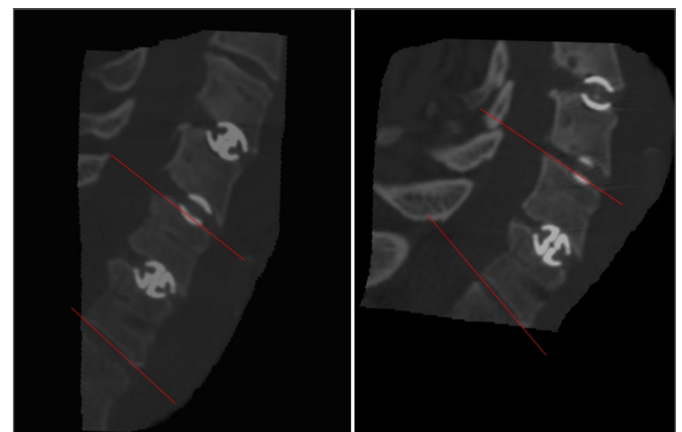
Sagittal 80° range of motion (ROM) of the functional spinal unit, which was defined as the angle formed by lines drawn at the superior margin of the upper vertebral body and the inferior margin of the lower body on fine spiral CT section of flexion and extension in the median sagittal plane.
